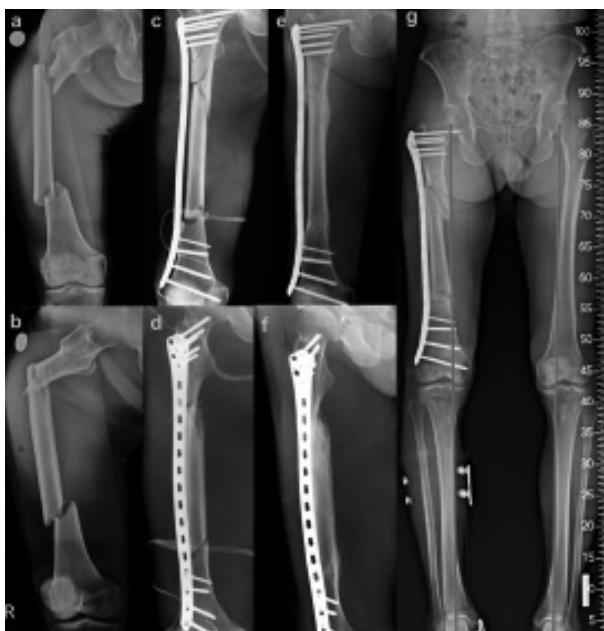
(a,b) Subtrochanteric and distal shaft fractures of right femur. (c,d) Immediate post-operative radiographic images of MIPO with reversed DF-LCP fixation. (e-g) Radiographic images at post-operative 9 months.
